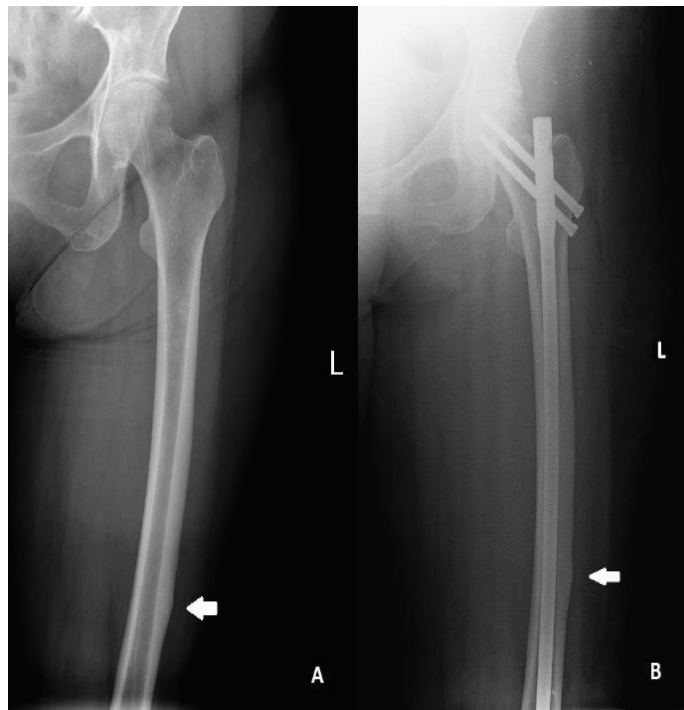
Atypical femur fracture A. Pre-operative AP plain radiograph of the patient. White arrow shows cortical thickening and cortical fissure. B. Post-operative AP plain radiograph shows prophylactic intramedullary nailing; white arrow shows persistent thickening.
